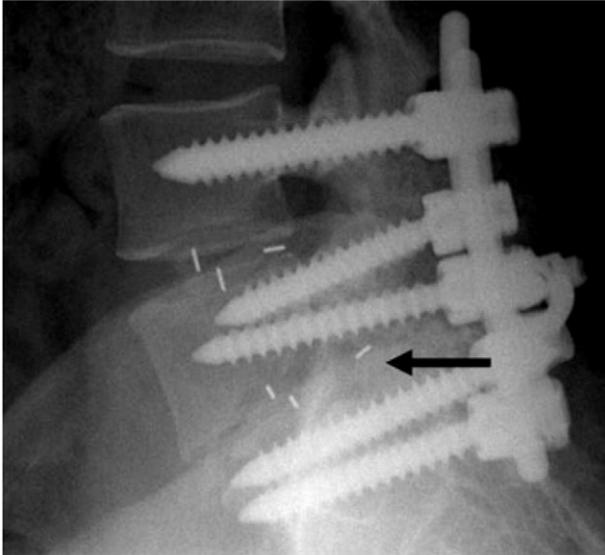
Lateral radiograph depicts posterior interbody fusion at L4-5 and L5-S1 and posterolateral displacement of the L5-S1 bone graft cage into the spinal canal (arrow). (Image provided courtesy of The Radiological Society of North America. From Young et al.¹.)
